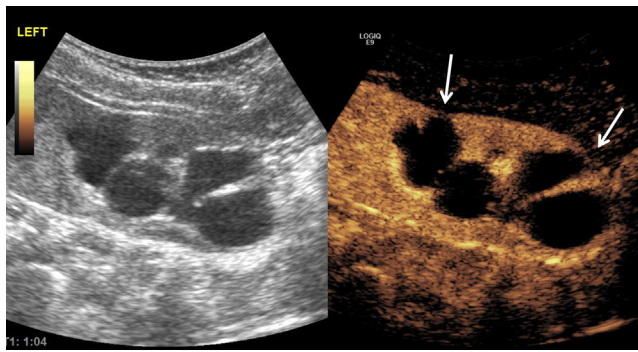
(Left) in patient CEUS-006, grayscale conventional ultrasound image demonstrating moderate hydronephrosis of the left kidney. (Right) contrast-enhanced ultrasound image taken at the same time and in the same plane as the grayscale image. Arrows highlight areas of parenchymal thinning and demonstrate the collecting system to apparently extend to the renal capsule with no intervening parenchyma between the surrounding soft tissue and collecting system.
